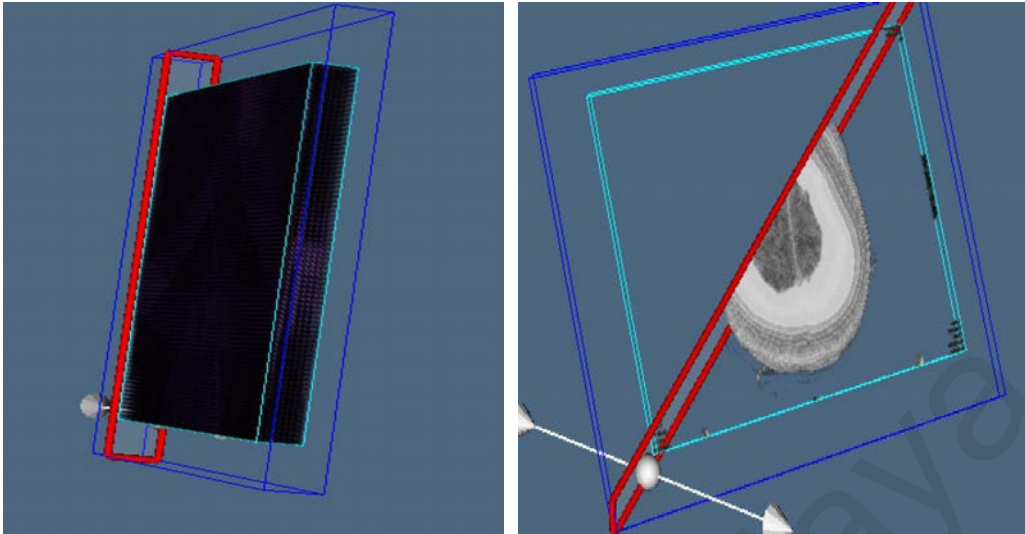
8 MRI brain volumetric rendering image (236x236)
